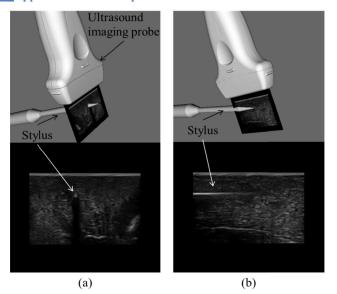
Ultrasound imaging and tracking in excised chicken breast tissue with (a) stylus perpendicular to the imaging plane, (b) stylus parallel to the imaging plane.
